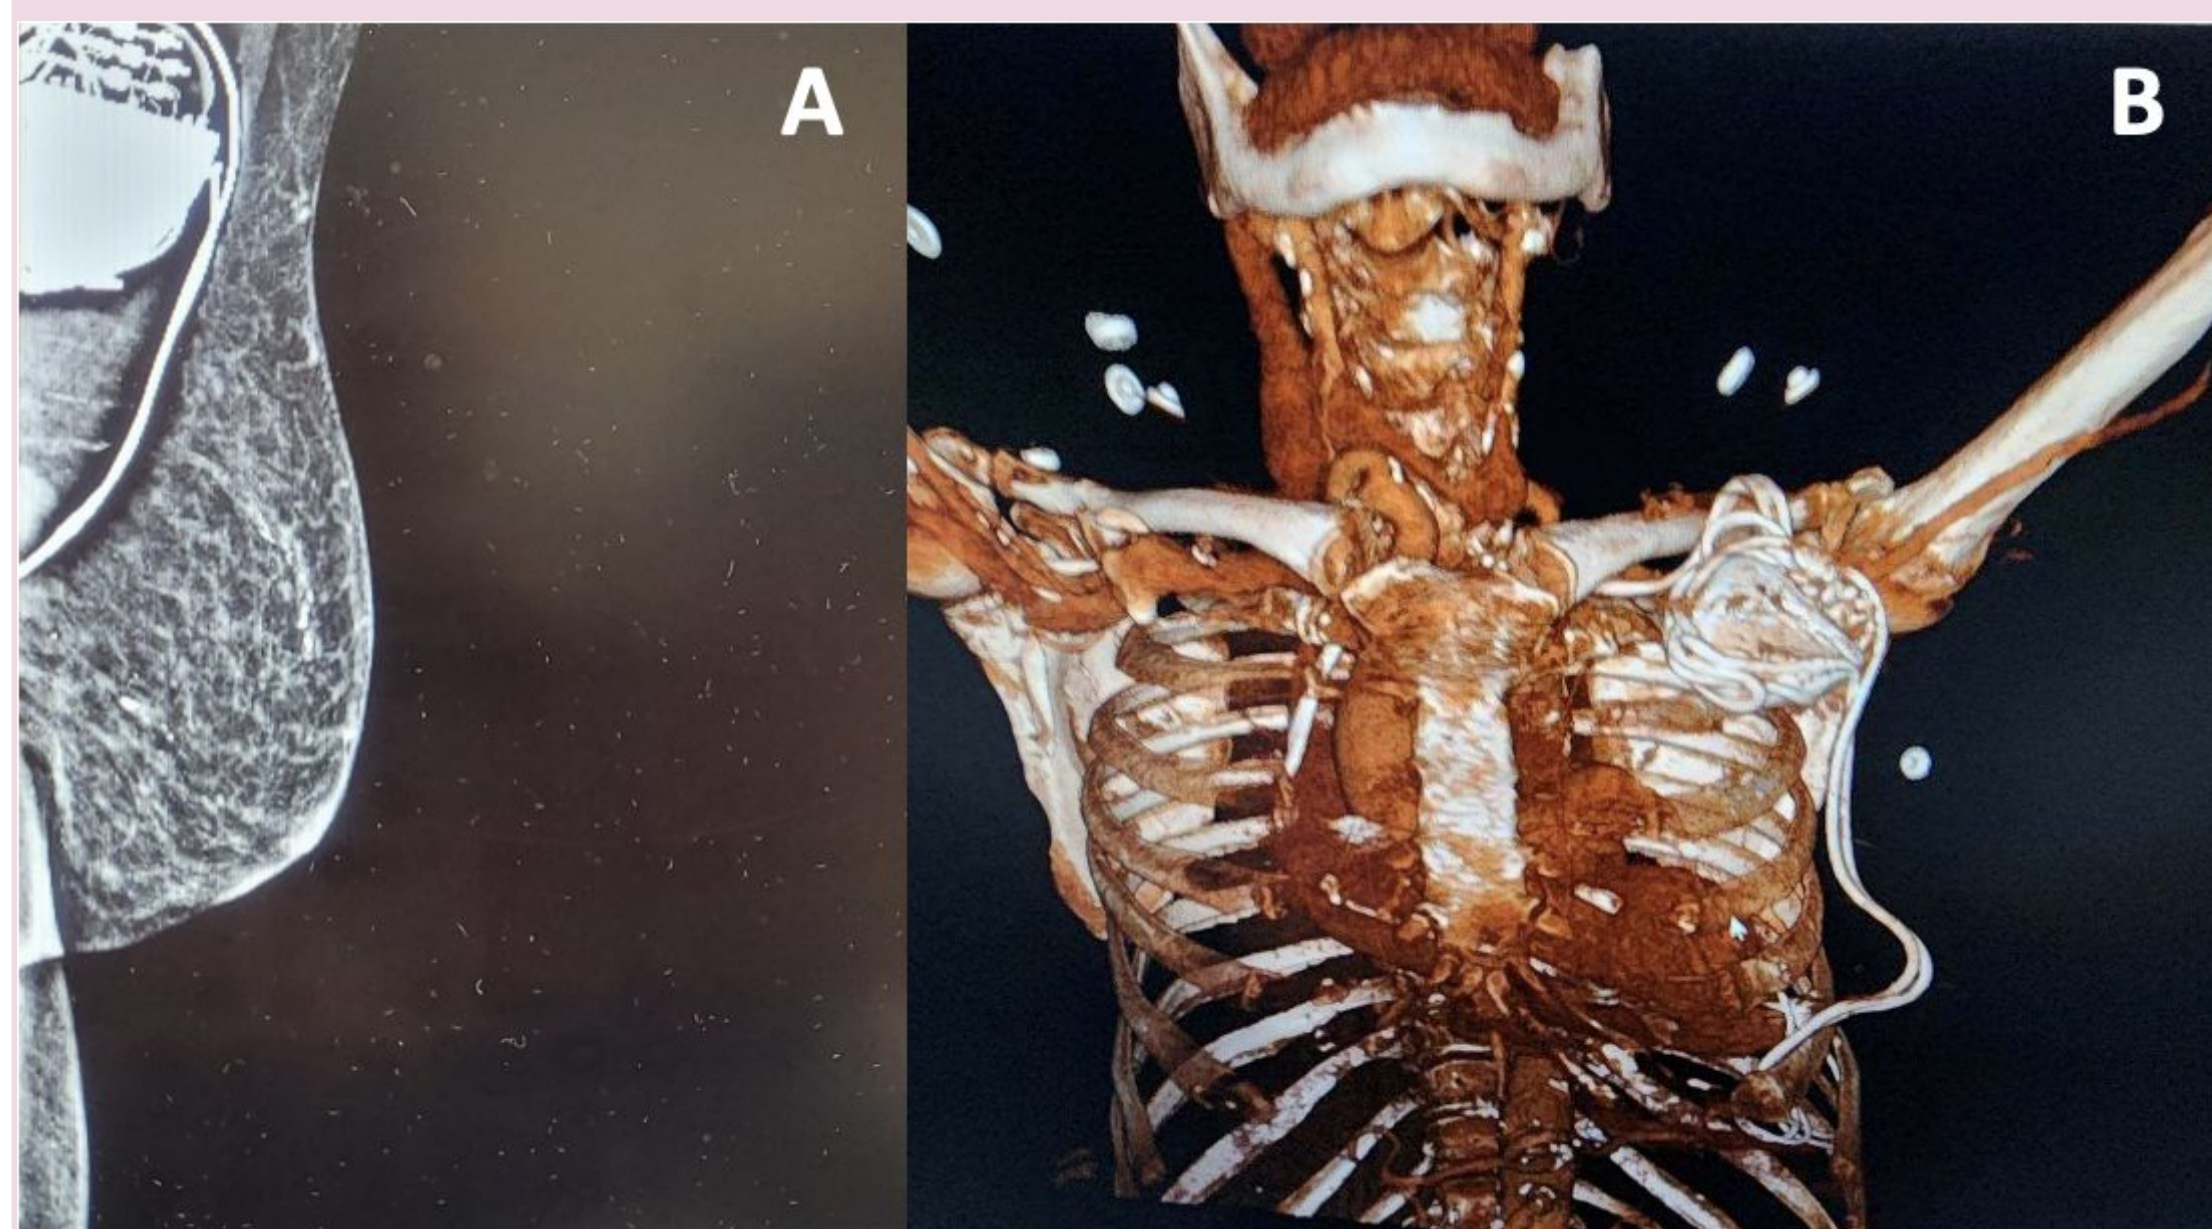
A) Preoperative mediolateral oblique (MLO) view diagnostic mammography B) Postoperative CT angiography confirming presence of the two epicardial pacemaker leads within the left breast
